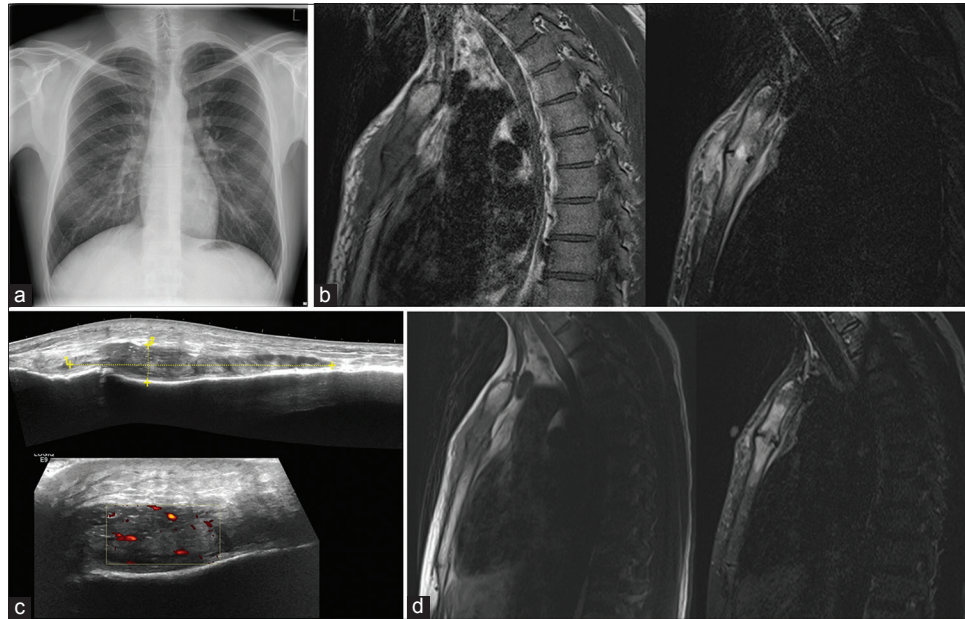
A 30-year-old male presented with a 4-week history of chest discomfort and pain. Blood tests including white cell count and inflammatory markers were normal and the patient suffered from no systemic symptoms. (a) Posteroanterior chest radiograph did not show any abnormality. The patient proceeded to magnetic resonance imaging for further evaluation. (b) Selected sagittal T1-weighted (left) and short-tau inversion recovery (STIR) (right) magnetic resonance imaging (MRI) through the manubriosternal joint. T1-weighted imaging demonstrates hypointense signal within both the manubrium and proximal sternal body with corresponding high signal on STIR imaging consistent with bone marrow edema. In addition, there is a low T1 weighted and intermediate to high STIR signal subcutaneous soft tissue changes seen at and anterior to the manubriosternal joint. (c) Ultrasound images at the level of the manubriosternal joint show a mixed echogenicity subcutaneous abnormality with increased Doppler flow corresponding to the MR findings. (d) Septic arthritis and SAPHO syndrome were raised as possible differentials. The case was discussed at a multidisciplinary meeting and decided a trial treatment with nonsteroidal anti-inflammatory drugs and follow-up imaging in 1 month. No antibiotics were used in patient management. Follow-up sagittal T1-weighted (left) and STIR (right) MRI show improved appearances and the diagnosis of synovitis, acne, pustulosis, hyperostosis, and osteitis was confirmed at this point.
